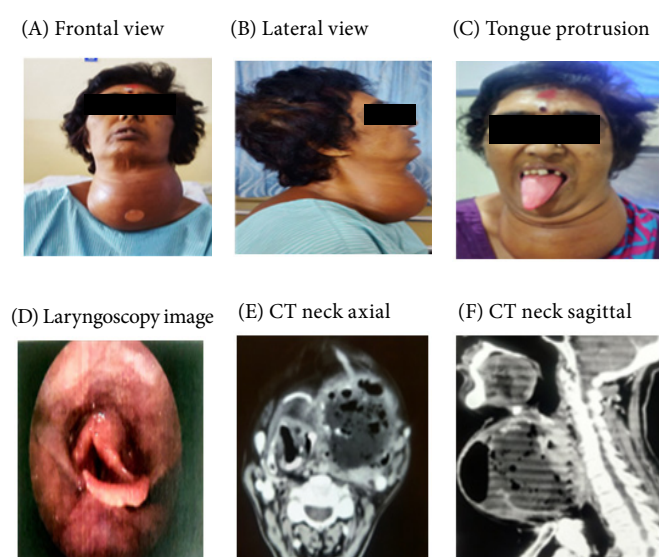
Clinical photographs of (A) Frontal view, (B) lateral view, and (C) tongue protrusion in case 1 with a large anterior neck swelling. (D) Video laryngoscopy image showing distorted laryngeal anatomy. (E) Axial and (F) sagittal computed tomography (CT) images demonstrating a large thyroid mass with significant tracheal compression and deviation.
